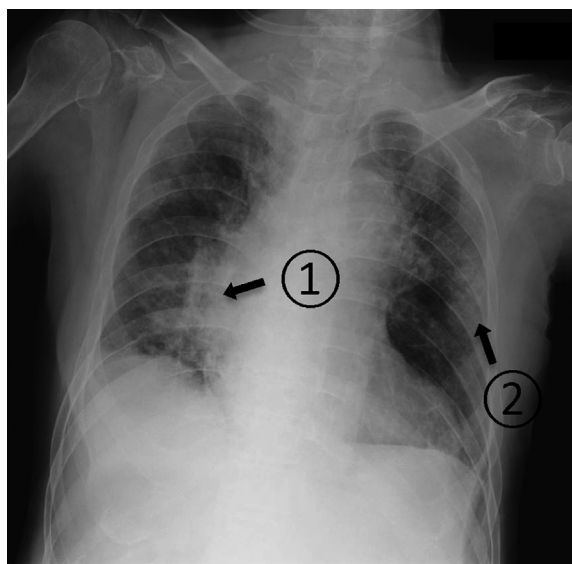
Chest X-ray of the patient on admission day 1. A chest radiograph shows bilateral pulmonary infiltrates. Arrow 1 indicates an infiltrative shadow overlapping the second arch in the middle to lower field of the right lung, while arrow 2 indicates consolidation with air bronchograms on the lateral side of the left middle lung field.
